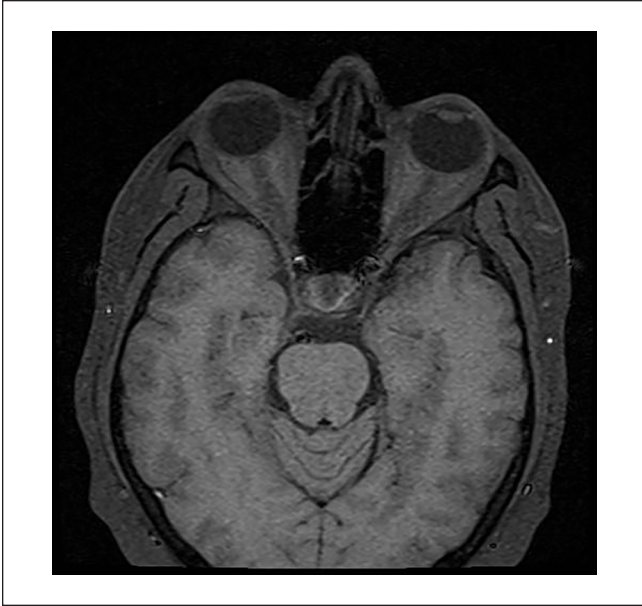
Axial orbital magnetic resonance imaging pre gadolinium contrast showing right optic nerve has a slightly ill-defined appearance more than left.
